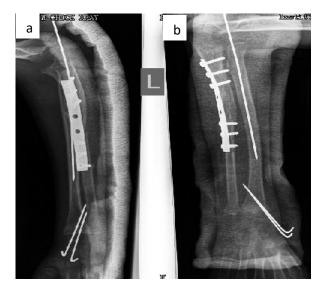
(a, b): X-ray at 4 weeks post-op.
